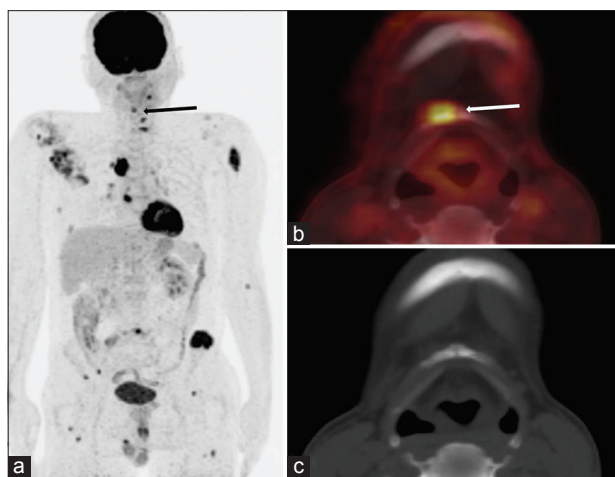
In the maximum intensity projection image (a), it showed recurrence in the right renal bed and metastases to bilateral lungs and multiple skeletal sites including a rare site of hyoid bone metastasis (black arrow). Transaxial positron emission tomography/computed tomography and computed tomography images (b and c) showed lytic lesion in hyoid bone with increased tracer uptake (white arrow), suggestive of hyoid bone metastasis
